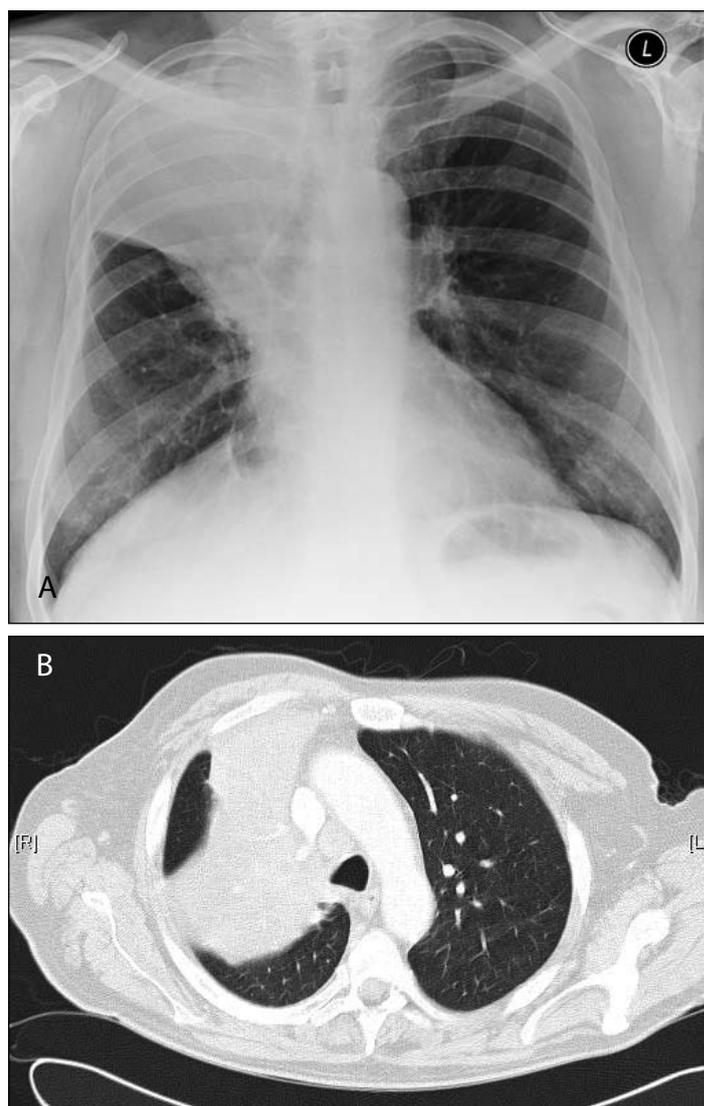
(A) Chest Xray and (B) CT showing right upper lobe collapse/consolidation secondary to a right upper lobe tumour
